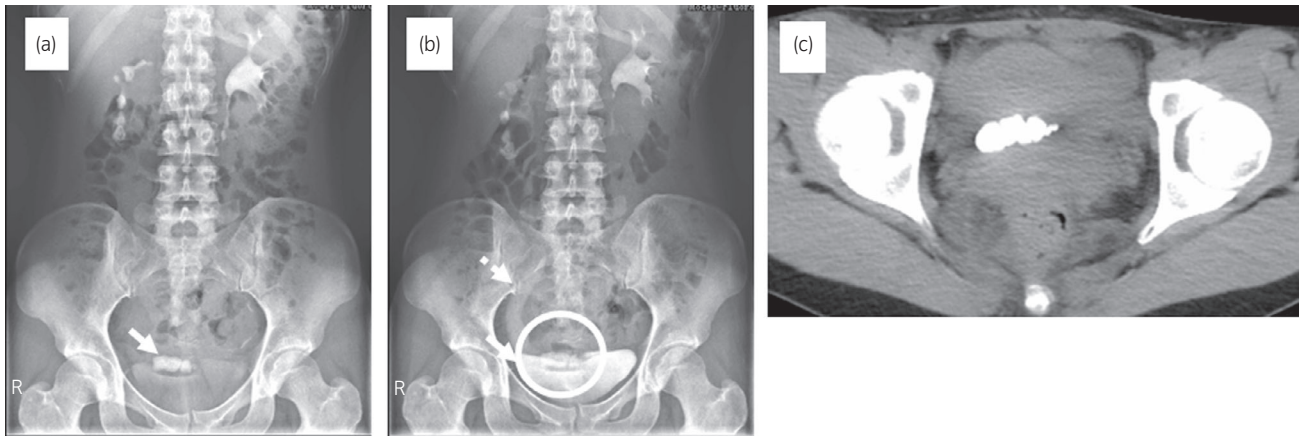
Intravenous pyelography (a), (b), and CT radiography at pre-operation (c). The arrow and circle reveal right ureteral stones in distal ureter after Cohen procedure for VUR 23 years ago. The dotted arrow indicates a right hydronephrer.
